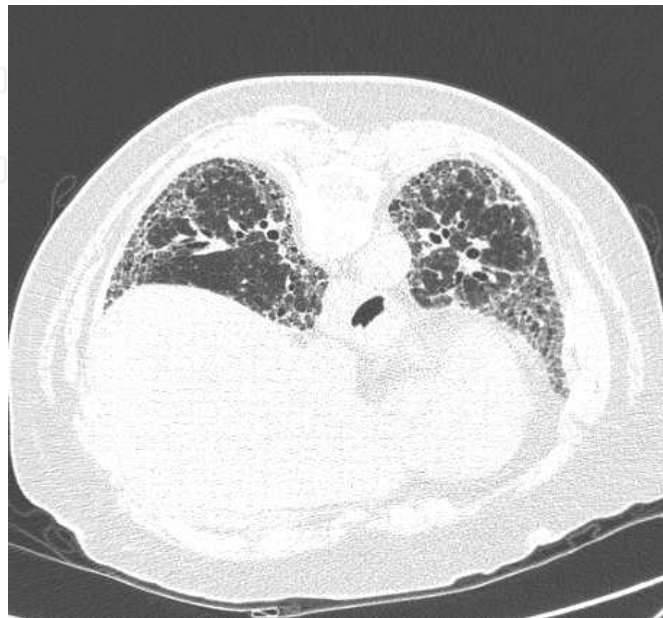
Thoracic HRCT slice from a patient with IPF demonstrating bilateral peripheral and basal fibrosis, with honeycomb cysts and traction bronchiectasis.
